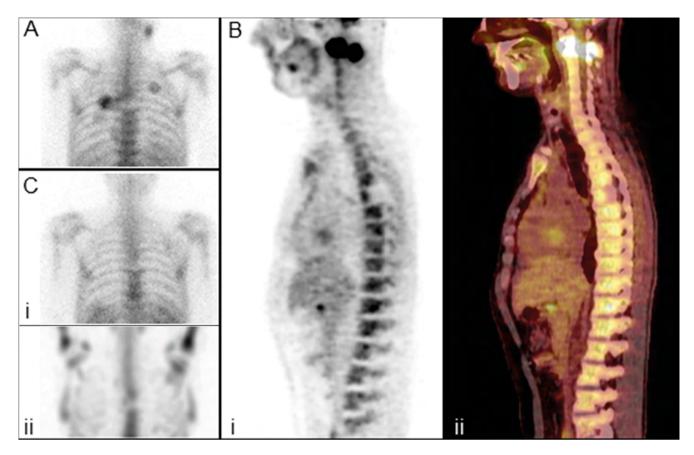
(A) Posterior planar [67Ga]Ga-citrate image of the chest shows diffuse increased skeletal uptake and a photon-deficient lesion at the level of the T6 vertebra. (B) Sagittal [18F]FDG PET (i) and PET/CT (ii) slices demonstrate the prominent metabolic activity with slightly heterogeneous distribution within the vertebral bodies and a hypometabolic area in the posterior T6 vertebral body. (C) Posterior planar view of the thorax (i), and posterior view of the maximum intensity projection (MIP) with single-photon emission computed tomography (ii), show that the cold lesion remained unchanged on [67Ga]Ga-citrate scan follow-up
